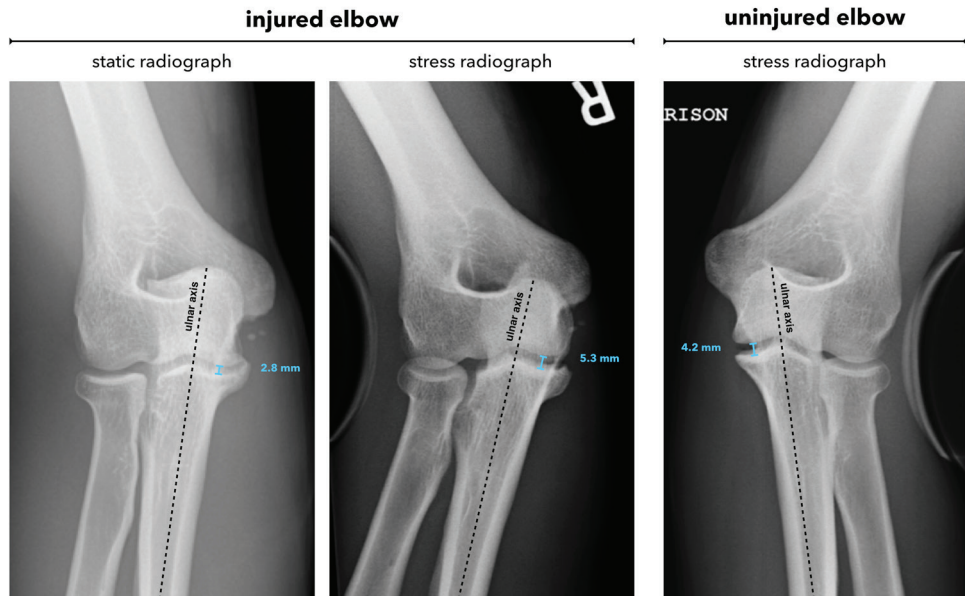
Measurements of joint space opening using the 1-line method on static and stress radiographs of the injured (2.8 and 5.3 mm) and uninjured (4.2 mm) elbow of a 22-year-old right-handed pitcher.
